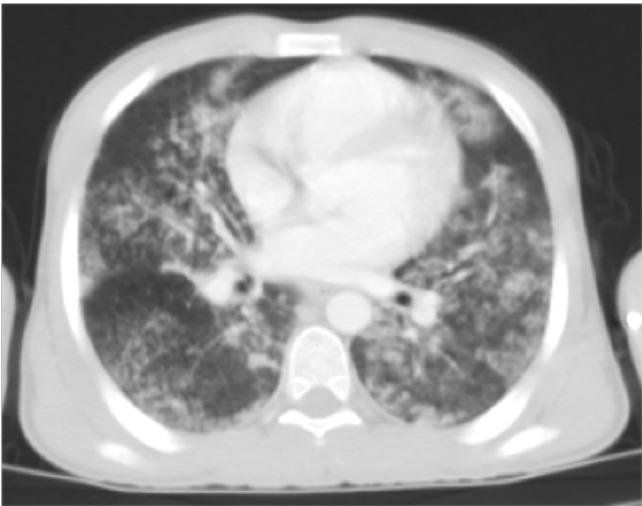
Parenchymal thoracic CT section; hemorrhage-related bilateral ground glass appearance
